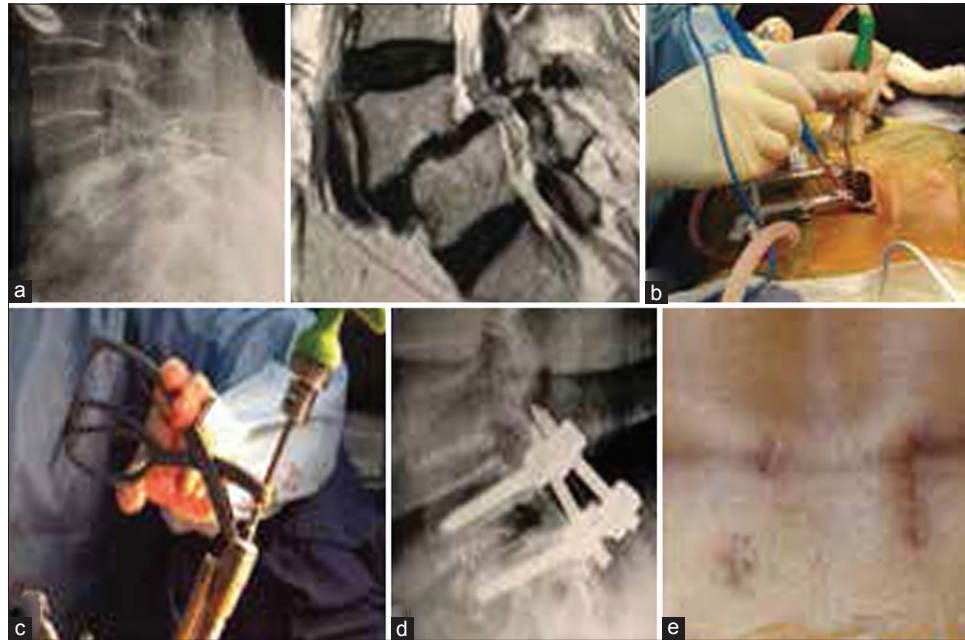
Clinical case demonstration: Minimal invasive-transforaminal lumbar interbody fusion in spondylolytic spondylolisthesis. (a) Preoperative radiograph lumbosacral spine and T2W sagittal MRI showing spondylolisthesis L4L5 vertebral body (b) Intra operative photograph showing decompression tubular retractor (c) Intraoperative photograph showing manipulation (d) Postoperative radiograph showing implant and cage *in situ* (e) Postoperative photograph showing scar mark
